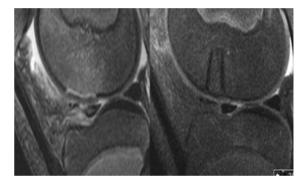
Same boy as in picture one. Left MRI after dislocation and OCF, which is best seen as abcence of subchondral plate. On the right same area 6 months post-sugery, where subchondral plate is restored and cartilage seems normal.
